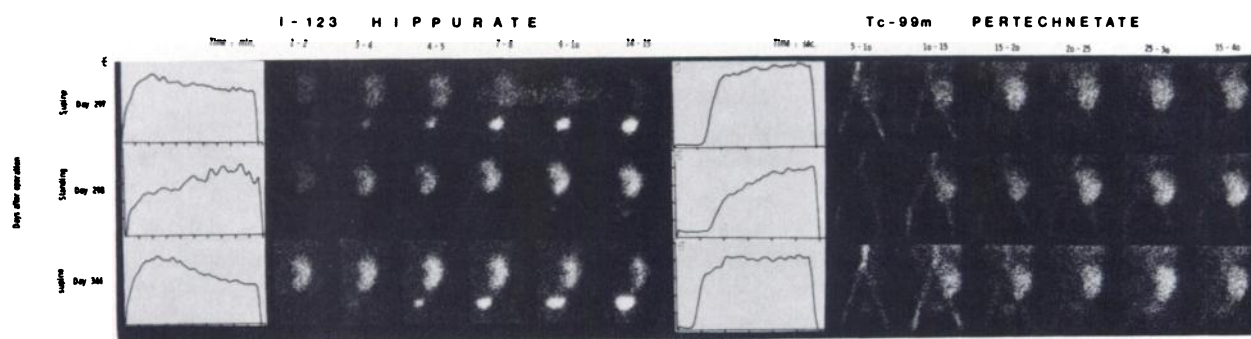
Patient 1: Iodohippurate renography and perfusion scintigraphy in supine and standing positions. Standing produces sudden and massive deterioration of iodohippurate handling and pertechnetate flow. Note good repetition of supine flow curve on Days 297 and 344. Renal-artery stenosis was verified by angiogram.
